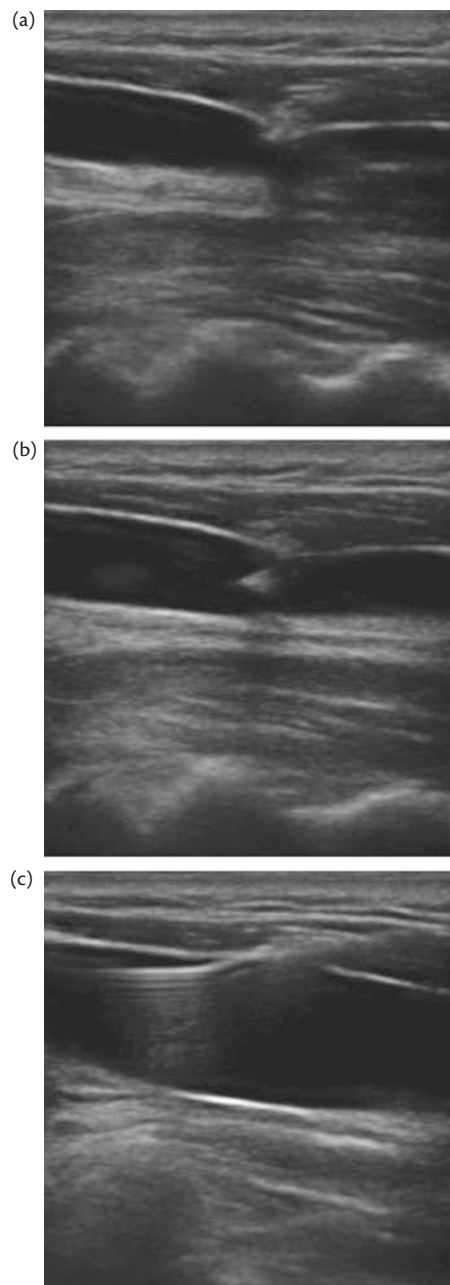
Ultrasound-guided insertion of needle and guide wire to internal jugular vein. The needle tip is identified throughout its path from skin to vein lumen (a). This requires precise positioning as the needle shaft may be confused with the tip. Once the needle tip is visualized within the lumen (b), the guide wire is passed and confirmed to lie within the vein (c).
